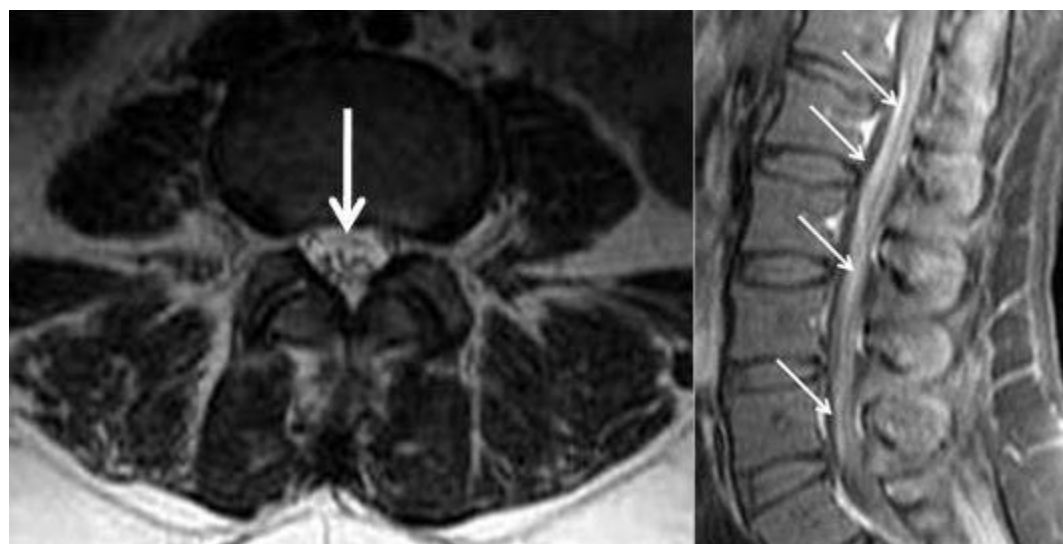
MRI imaging of the spinal cord of a patient with GBS. Disc herniation at T12-L1 is shown. Image retrieved from <http://www.radiologycases.com/casereports/jrcr-tp.cgi?case=153#.Vu3cDuIrLIU>
